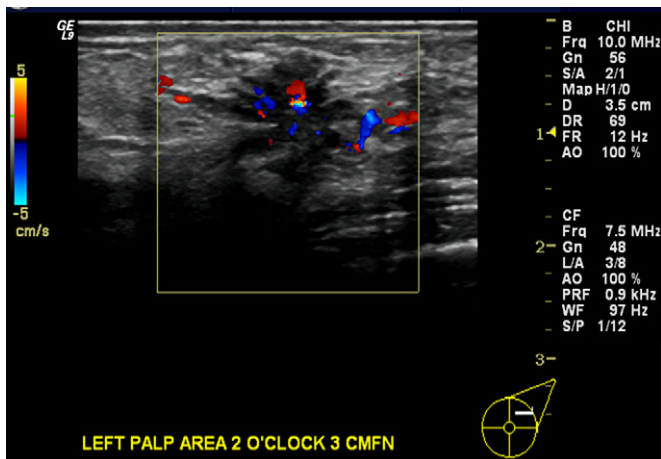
Transverse Doppler image, showing a hypoechoic area with marked distortion and increased blood flow. A 24-year-old woman presented with a palpable lump. Pathology results proved radial scar.
